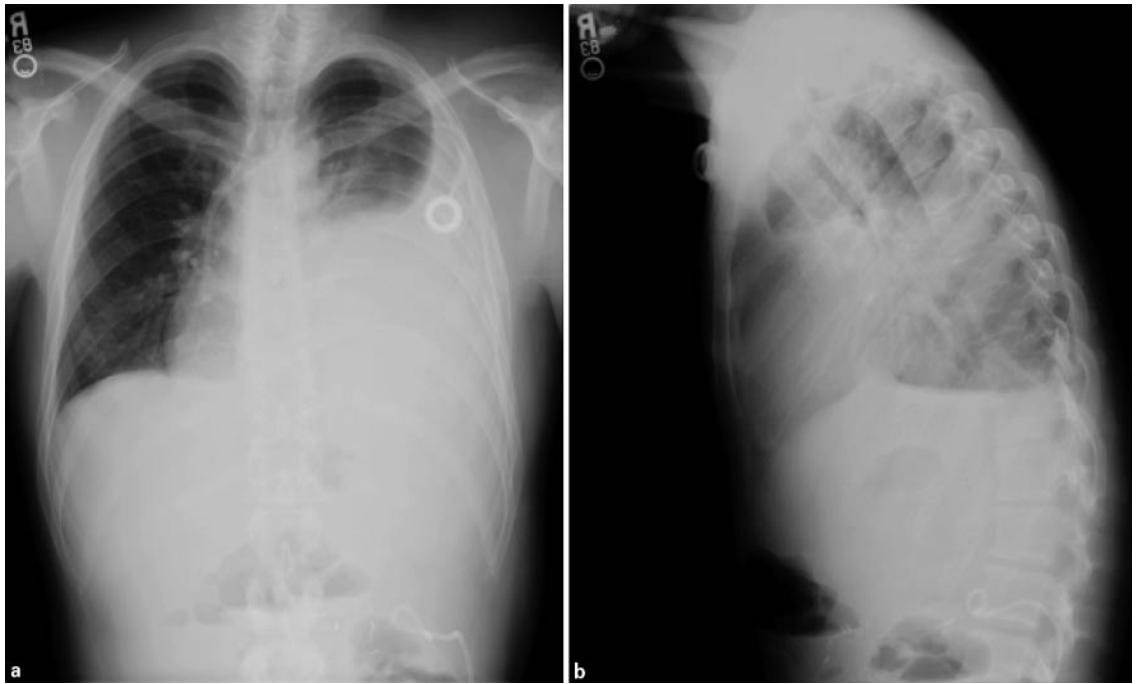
PA (a) and lateral (b) chest radiograph of a patient with left MPE prior to the insertion of the PC.
